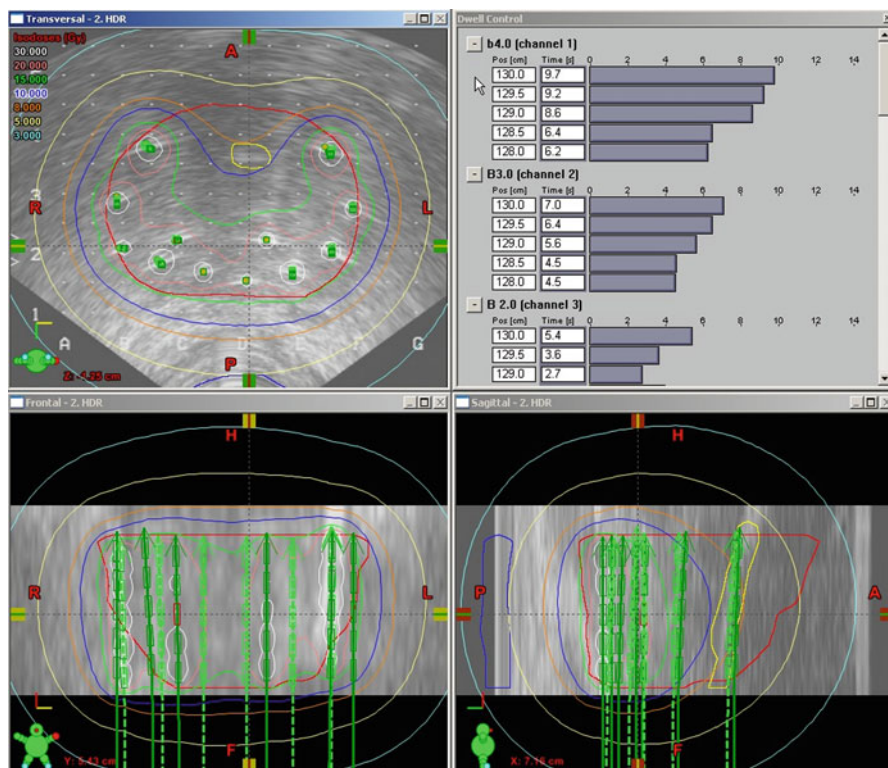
Screenshot of an ultrasound-based HDR real-time plan. A dose of 15 Gy (green isodose line) is prescribed to the periphery of the prostate gland. Upper right dwell times for the first two channels are shown. The first dwell position is at 130 cm
